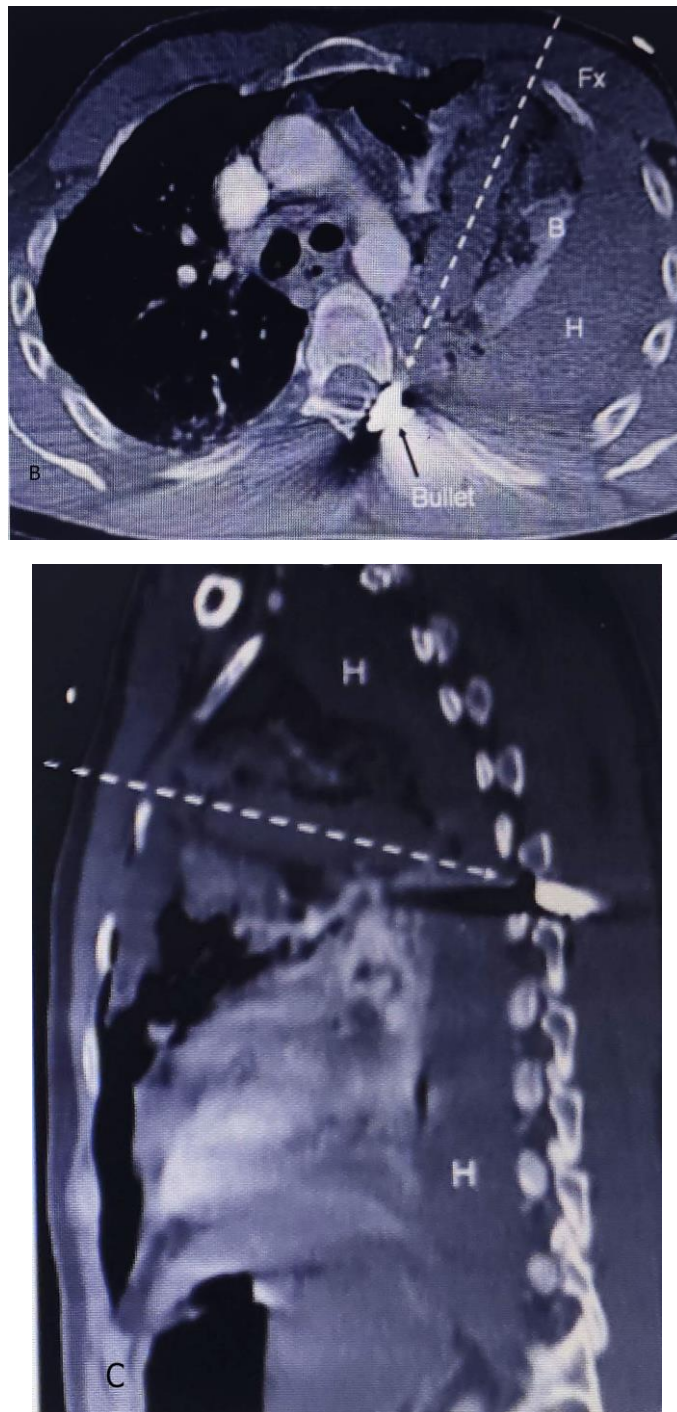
Bullet penetrating blind wound. Metal ball in the projection of the mediastinum on the left (A). The contusion zone (compaction with fuzzy contours) is adjacent to the ball with its apex. "Foggy" (cloud-like) compaction (hazy opacity) in the lower parts of the left lung and costophrenic angle is caused by hemothorax. Paraxial oblique (along the wound channel) CT. The wound channel is filled with blood, fragments of destroyed tissue. Compaction of the lung tissue in the zone of temporary pulsating cavity corresponds to fluid on the Hounsfield scale. Large hemothorax (H). C - large vessels are intact, signs of active bleeding from small vessels. Bullet in the costovertebral angle.
